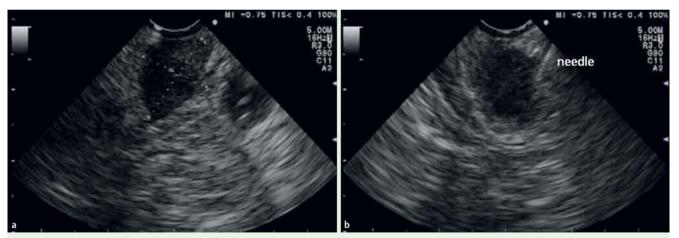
a Endoscopic ultrasound (EUS) view of the subepithelial lesion in the terminal ileum, demonstrating a hypoechoic lesion measuring 14×10 mm and confined to the submucosal layer. b EUS-guided fine-needle tissue acquisition from the lesion using a 19-gauge needle.
